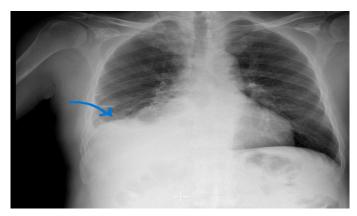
There is a pleural effusion and an enlargement in the heart shadow in the marked area on the chest x-ray.
